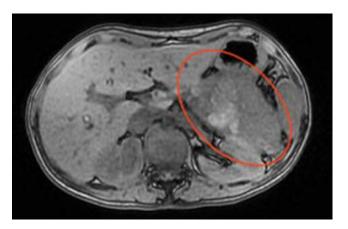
MRI of the abdomen with a contrast medium. Source: Authors' archive.
